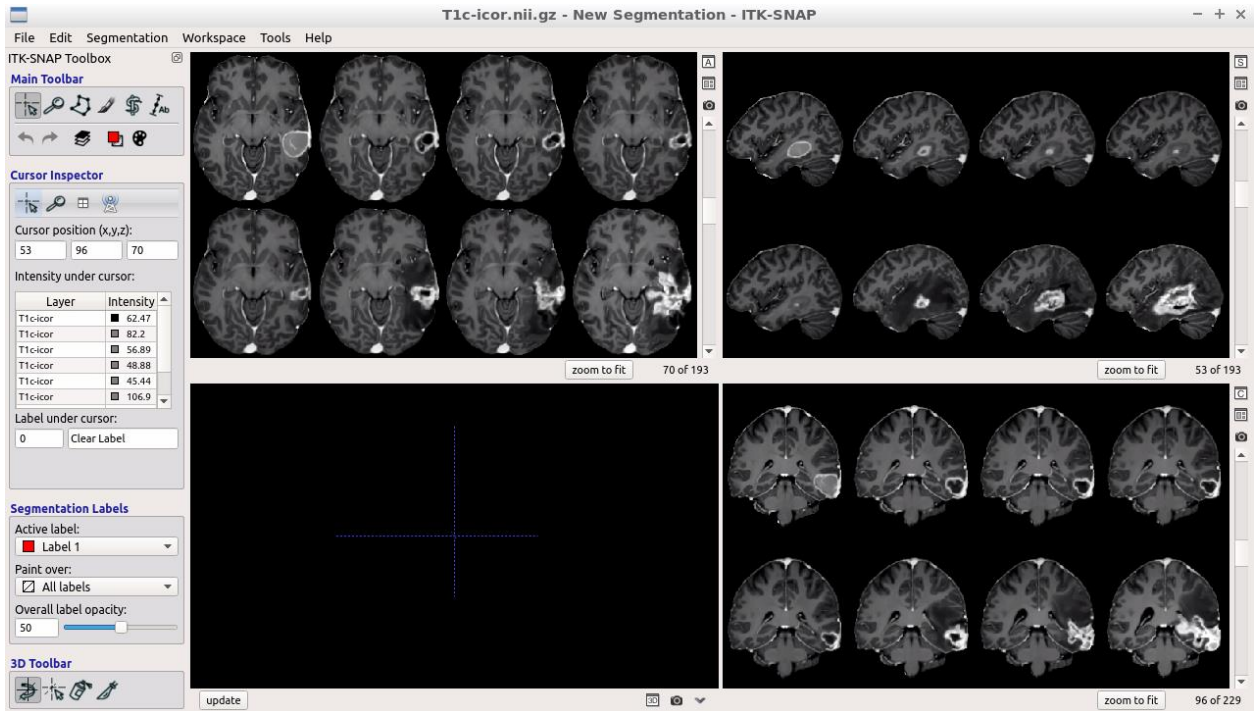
Scriptable visualization of preprocessed T1wc MRI in ITK-SNAP. This is subject nine from our second cohort.
